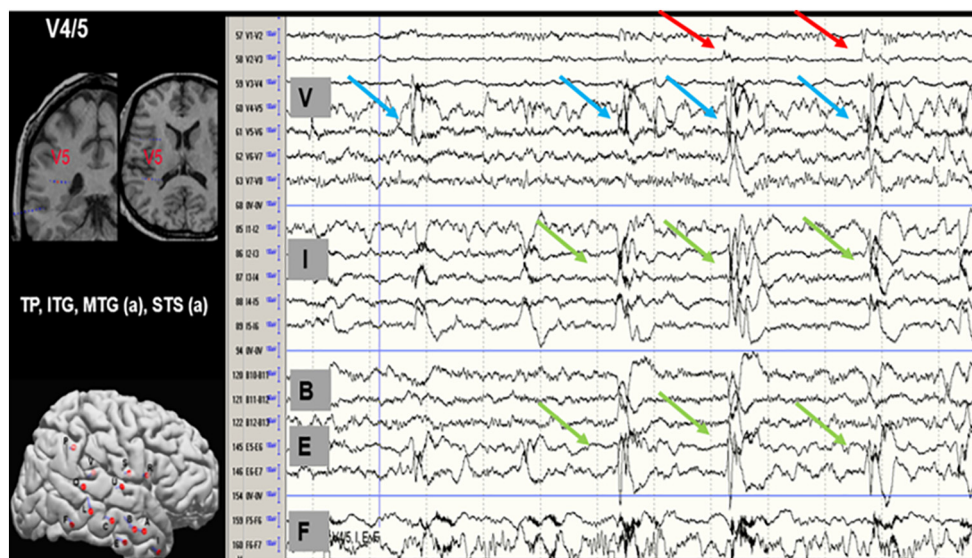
Interictal activity. The left panel shows the anatomical locations of the recording sites (electrode V) on MRI and post-implantation map of recording electrodes. Localization of displayed electrodes' contacts: V1–2 in PNH, V3–5 in white matter, V6–8 in temporal operculum; I in temporal pole; B10–12 in superior temporal sulcus; E5–7 in lateral temporo-occipital sulcus; F5–7 in inferior temporal gyrus. Frequent interictal discharges are recorded in white matter (contacts V4–5; blue arrows) preceding or simultaneous with spikes in temporal operculum, temporal pole, superior temporal sulcus and inferior temporal gyrus (green arrows). Small spikes are seen in PNH (contacts V1–2; red arrows).
